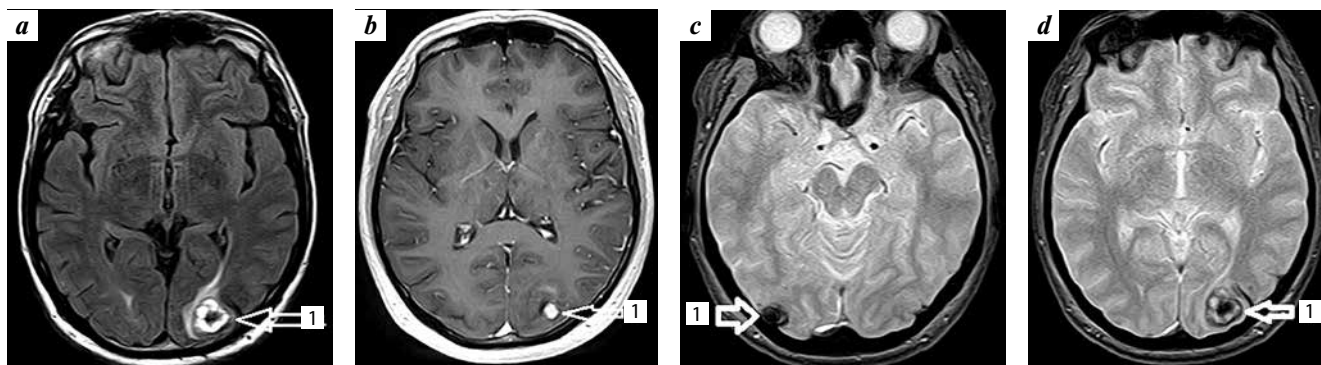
Mirror cavernous malformations of occipital lobes (MRI of brain dated 29.10.2019, 6 months after cardiac surgery): a – cavernous angioma (1) of left occipital lobe (MRI in the FLAIR sequence); b – cavernous angioma (1) of left occipital lobe with accumulation of contrast (sequence-WI with contrast enhancement); c – cavernous angioma (1) of right occipital lobe (MRI in sequence T2*); d – cavernous angioma (1) of left occipital lobe (MRI in sequence T2*) FLAIR (Fluid Attenuated Inversion Recovery) – the mode with suppression of free water signal, WI – weighted image, T1 and T2* – modes of sequences of weighted images on MRI.
